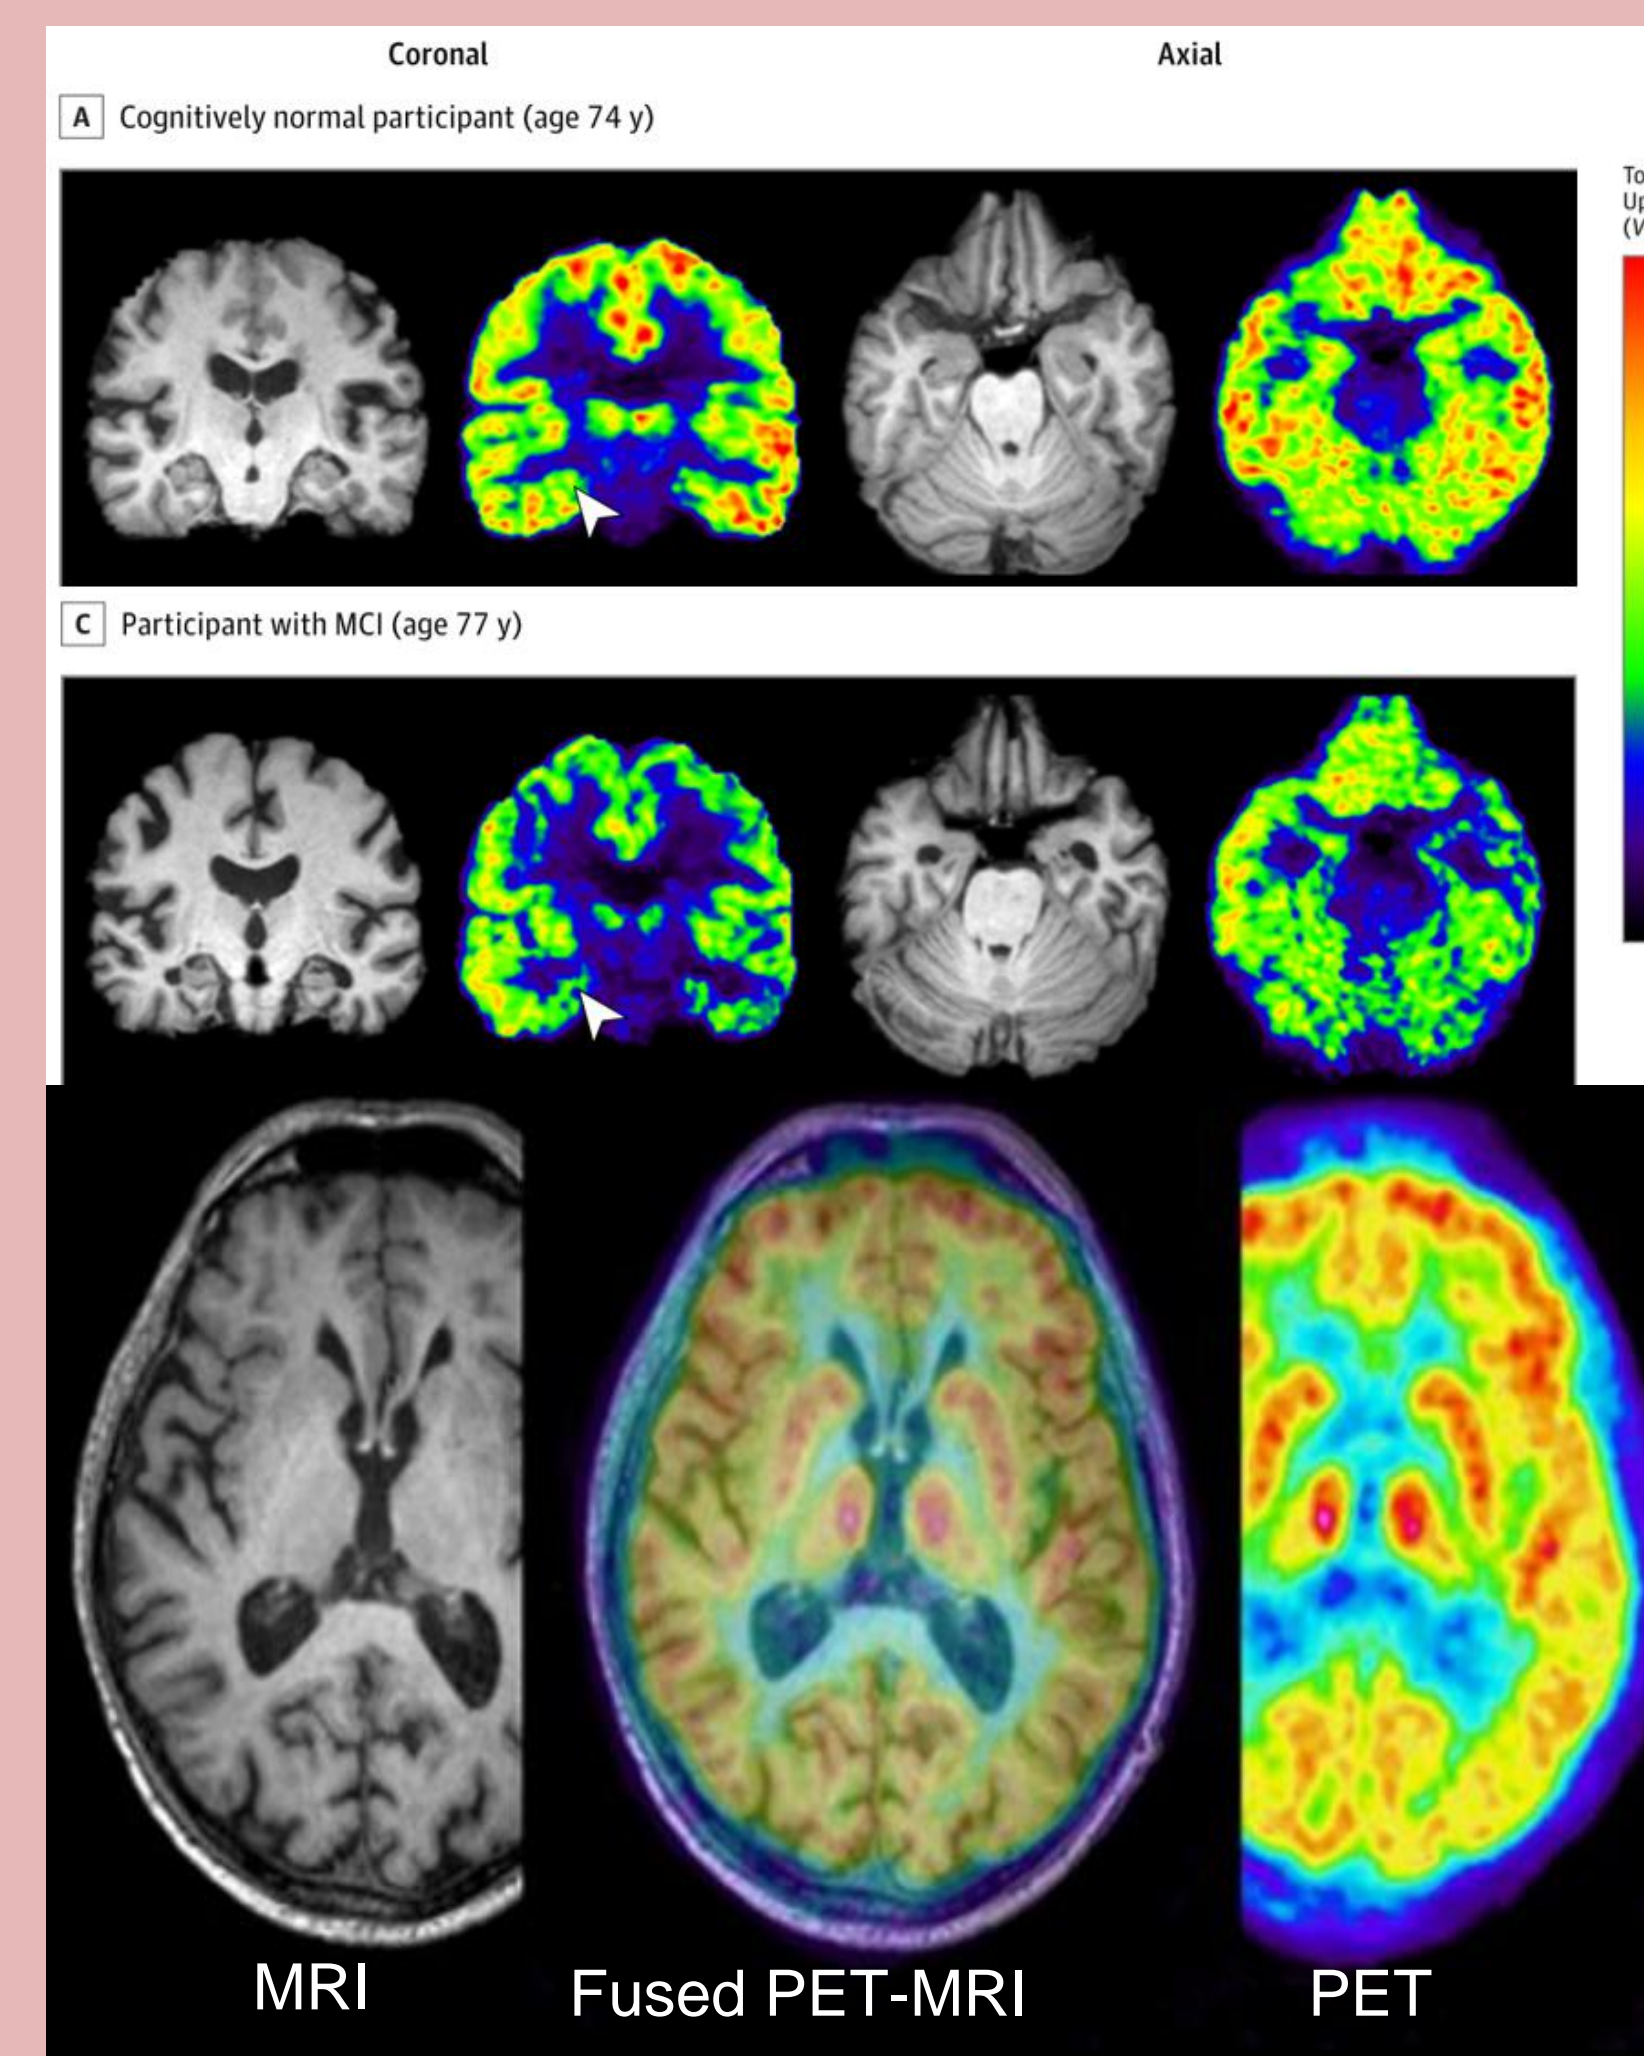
Top figures (A and C) are PET and MRI images of the brain of a PLWH and a HIV-negative control individual. Bottom figures show MRI and PET images overlaid to show structure and high activity areas.
